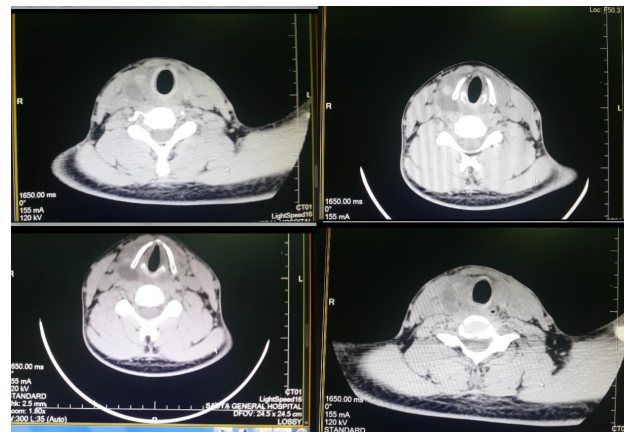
CT scan showing heterogeneous enlargement of the thyroid gland with some deep cervical lymph node enlargement
